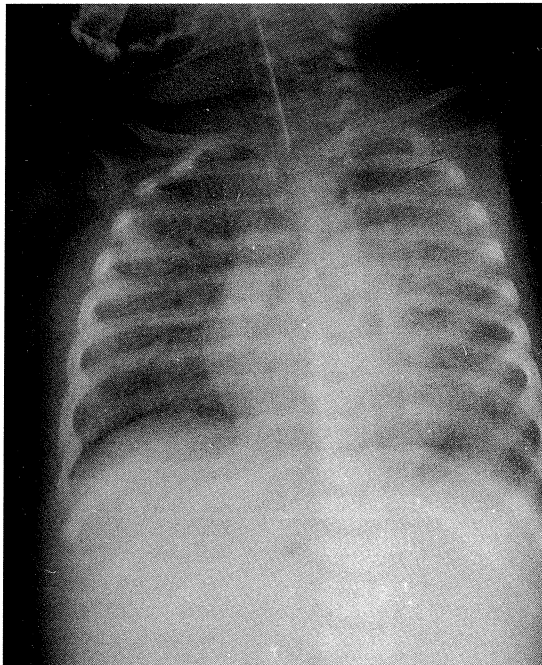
Bilateral infiltrates on radiograph.
